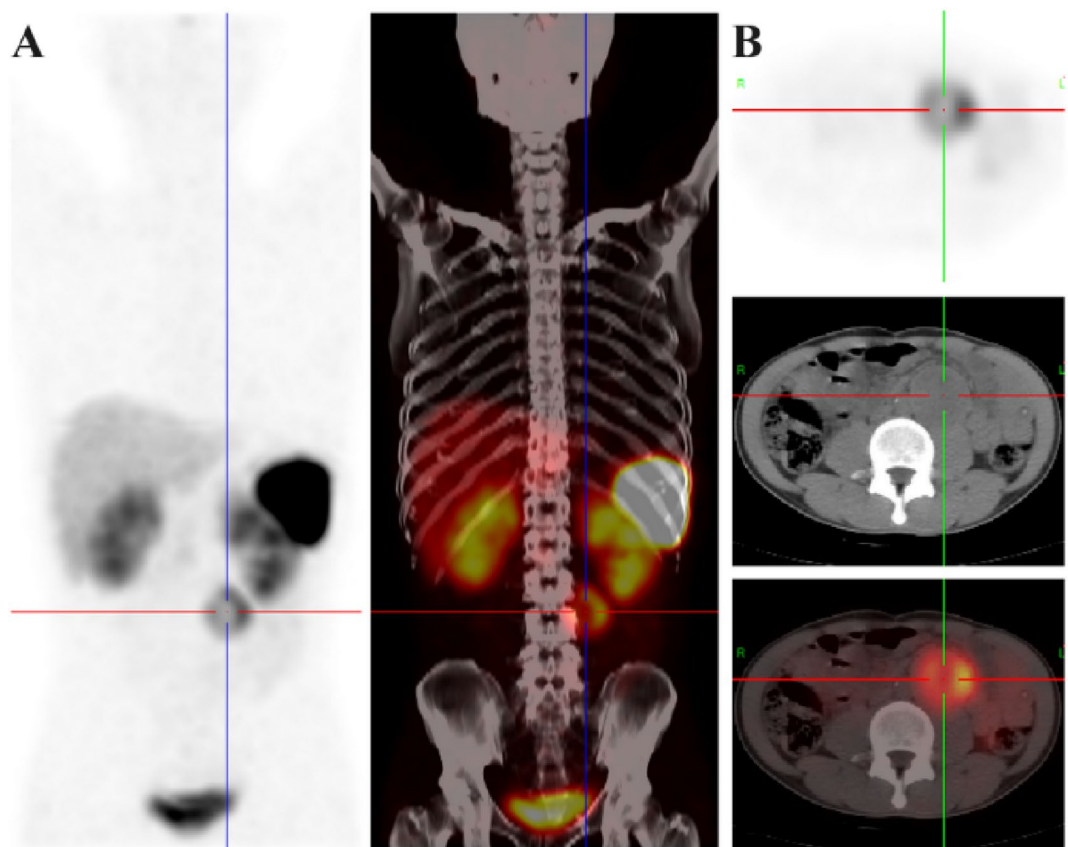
A 27-year-old male with uncontrolled hypertension. $[^{99m}\text{Tc}]\text{Tc-HYNIC-TOC}$ MIP image (A) demonstrates an area of abnormally increased radiotracer uptake in the left retroperitoneal region. SPECT/CT fused image (B) reveals a left retroperitoneal mass with a maximum diameter of 5.3 cm. The mass shows uptake of $[^{99m}\text{Tc}]\text{Tc-HYNIC-TOC}$, with a KS of 3 and a TBR of 3.00. The patient underwent surgery and was diagnosed with paraganglioma.
